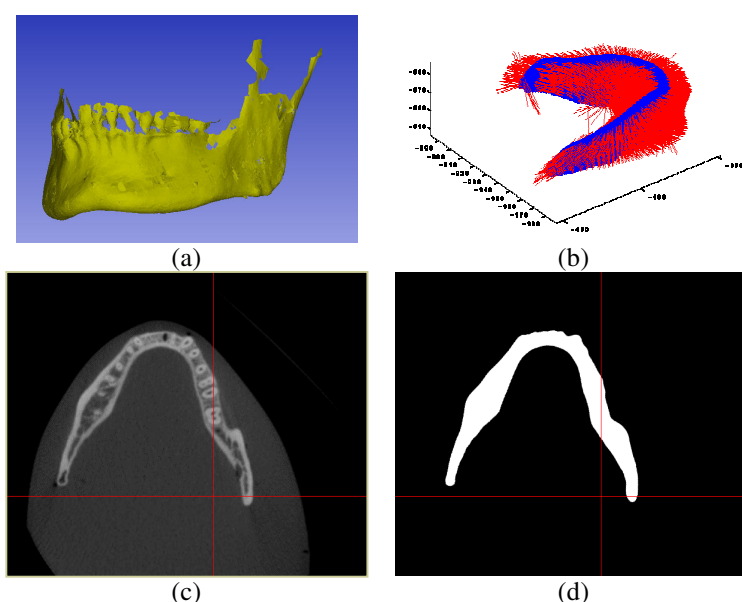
This figure gives an overview of the method for the validation of the image quality by comparing a 3-D laser scan (a) with a CT image (c). Using implicit functions, the point cloud is converted to a label image (d), which is registered to the CT image (c). The validation is performed along boundary points on the point cloud (b).
